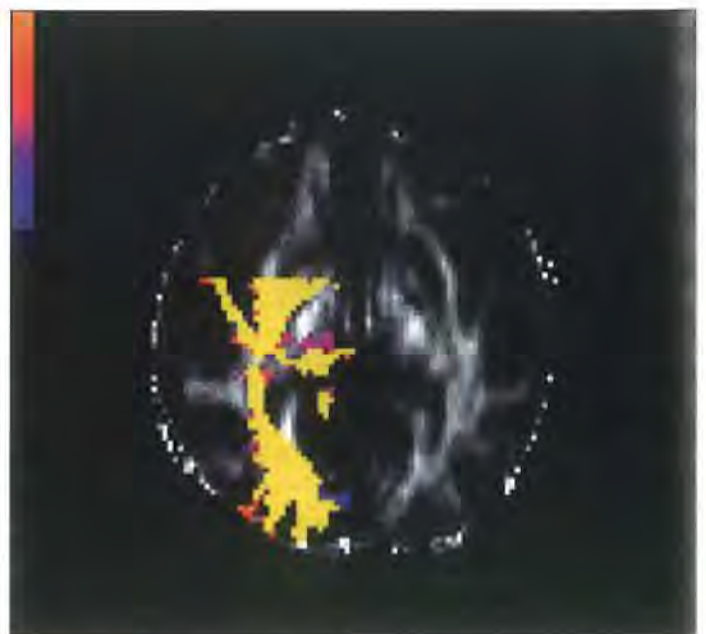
Diffusion tractography map generated from diffusion tensor MRI showing the optic radiation (indicated in yellow). Kindly provided by Dr Olga Ciccarelli.
